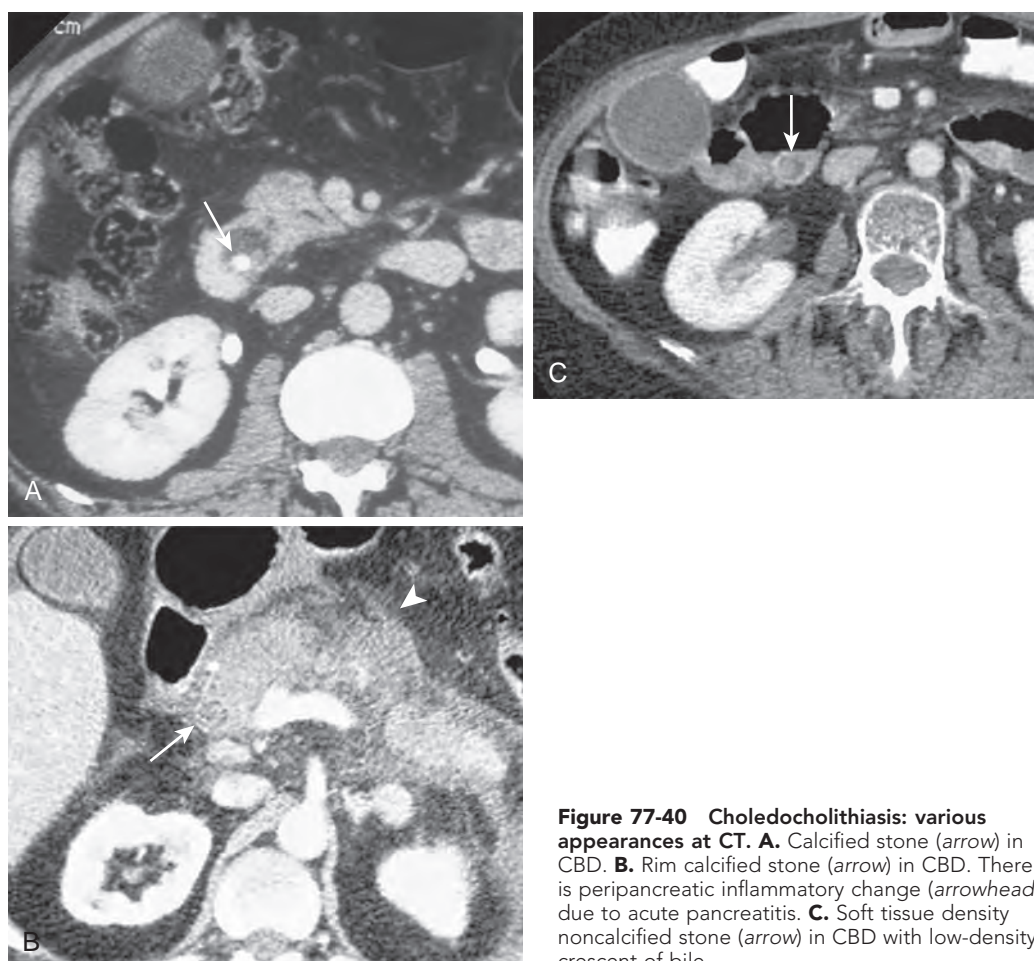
Choledocholithiasis: various appearances at CT. A. Calcified stone (arrow) in CBD. B. Rim calcified stone (arrow) in CBD. There is peripancreatic inflammatory change (arrowhead) due to acute pancreatitis. C. Soft tissue density noncalcified stone (arrow) in CBD with low-density crescent of bile.
